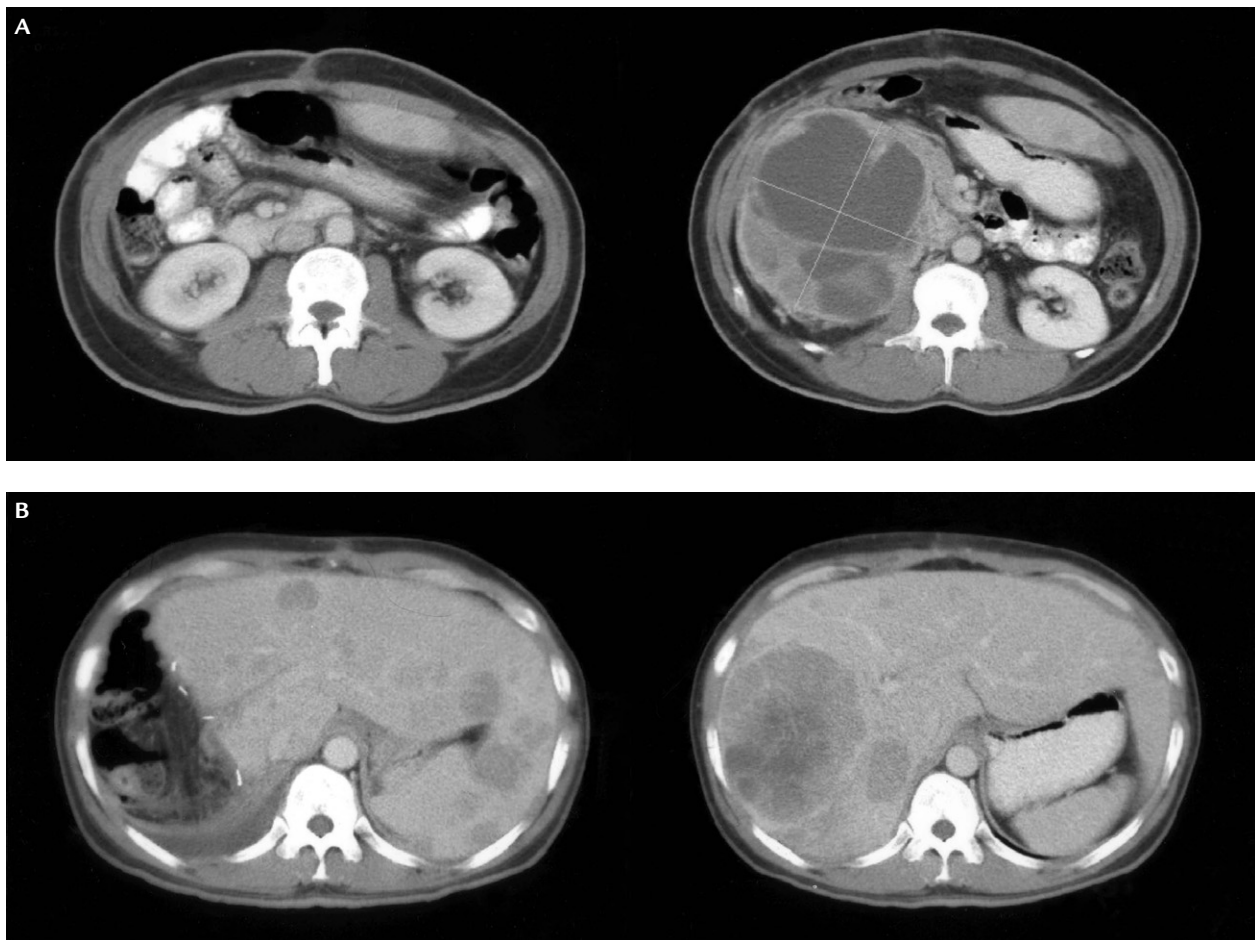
(A) Computed tomography (CT) on the left shows post eventual debulking surgery performed for the large primary retroperitoneal tumour that is shown at its largest diameter on the right. (B) Left: CT 1 month after right hemihepatectomy with bilateral lobe liver metastases. Right: CT shows the largest liver metastasis before resection.
